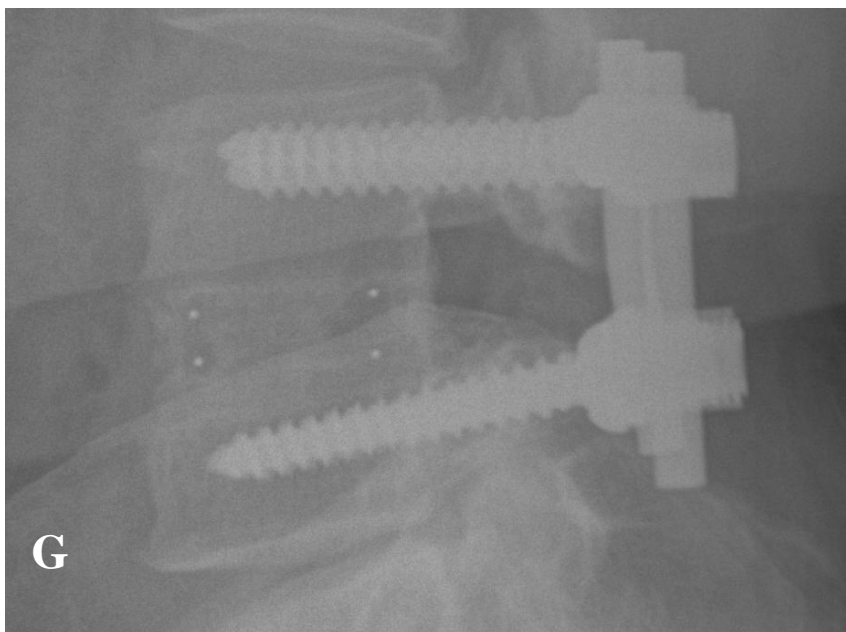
Criteria for bone fusion. Patients who showed more than 5 degree angulations on flexion – extension dynamic view defined as instability and non-fusion state (A, B). Traction spur (C), incomplete posterior bony bridge (D) and dark halo around the cages (E) were also defined as a non-fusion state. Patients who showed complete bony bridge without instability, traction spur and dark halo around the cages were defined as a fusion state (F, G and H). Some patients who underwent lumbar CT showed complete bone fusion state on sagittal reconstruction images (I).
